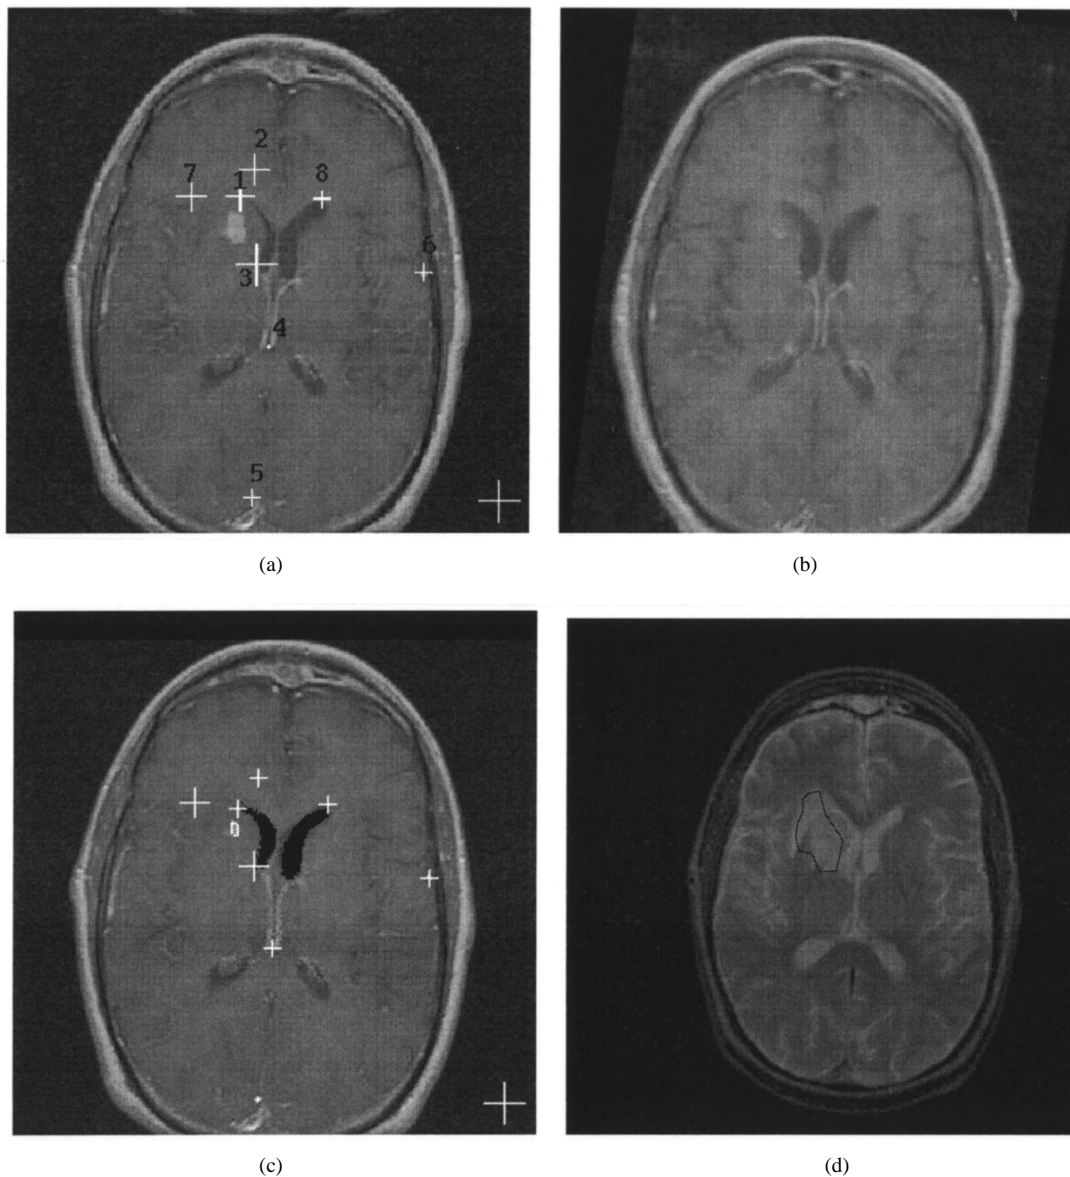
Verification using time series data. (a) Axial MR image with tumor intact. (b) Same patient image at a later time after tumor radiosurgery has shrunk the tumor. (c) Our regression pre-tumor image. The crosses in (a) and (c) represent the distance in eight landmark registration between (a) and (b) and (c) and (b). The error includes registration error and human error. Note that, overall, most crosses in (c) are smaller, which indicates that our regression results improve the registration process. Crosses in the lower right corners represent an error of 4 mm. An initial 20% (-0.2) strain uniform reduction of the edema was applied to the edematous region seen in the T_2 weighted image of (d) (dark outline).
